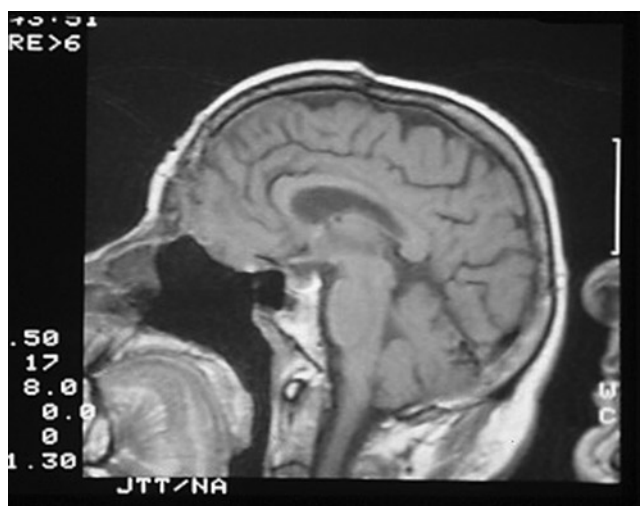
Sagittal postoperative MR image showing total ethmoidectomy with resection of the anterior wall of the sphenoid sinus
